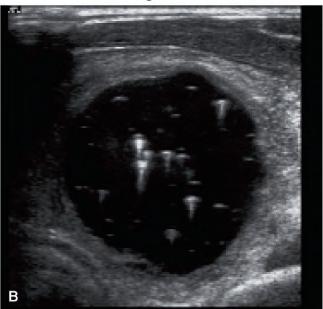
Ultrasound of a colloid cyst in the left lobe. A, Transverse, 22 x 25 mm. B, Longitudinal.
